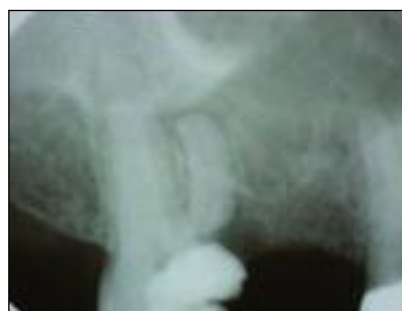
A digital periapical image of the upper right second molar and upper right second pre-molar, where the extent of the decay in the maxillary second molar is seen more clearly
